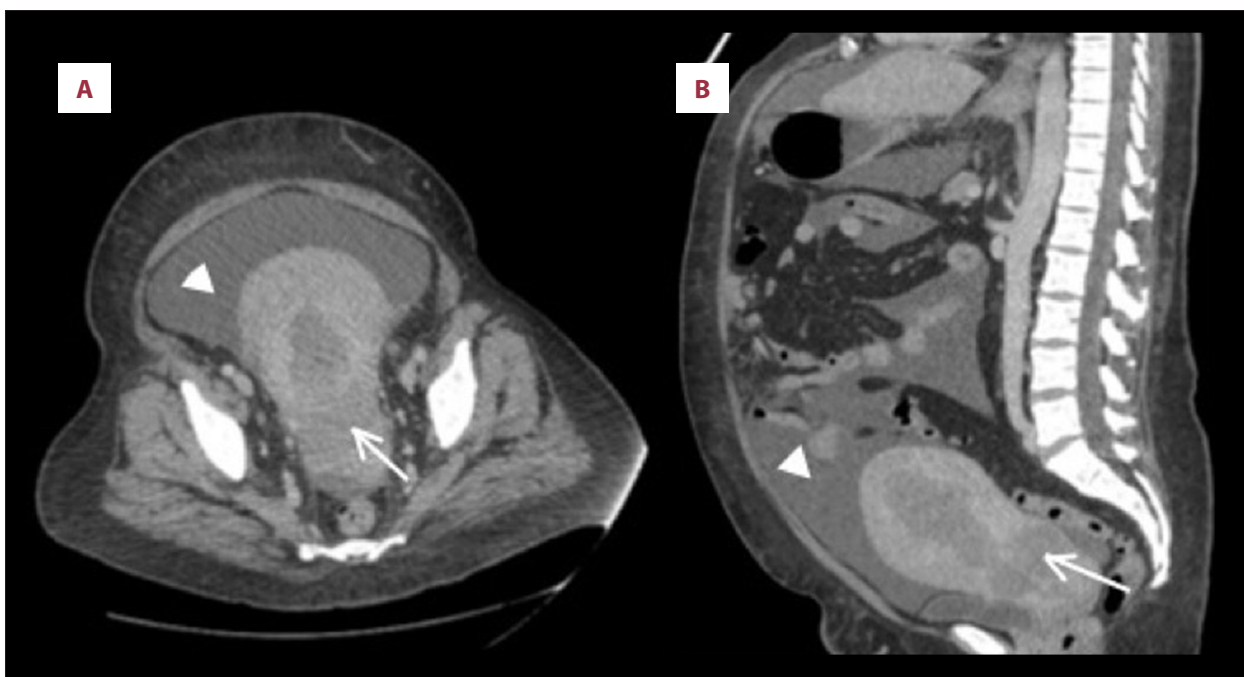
Axial (A) and sagittal (B) images of the patient's CT abdomen and pelvis, showing an irregular mass in the lower uterine/cervical region (arrows). Large-volume ascites is also seen (arrowheads).
